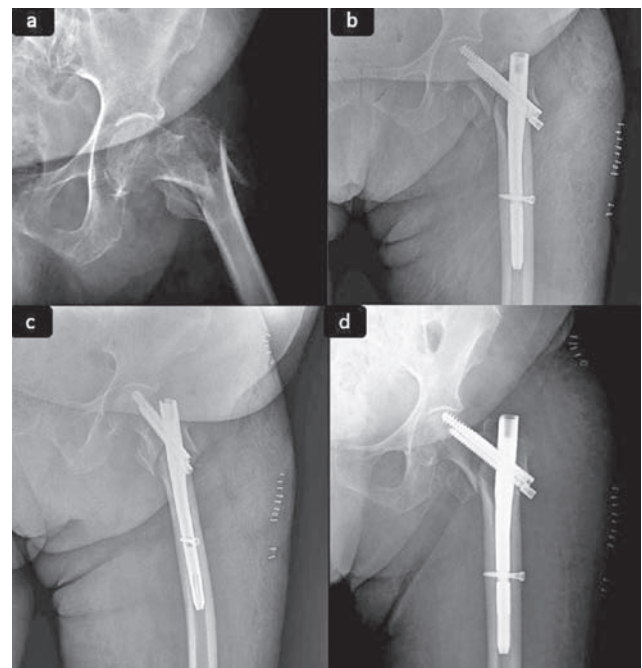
Varus Cut-off (a). Pre-operative X-rays (b and c). The fracture was fixed with negative medial cortical support, and the screws were placed high in the neck, both of which are risk factors for cut-out (b). AP view (c). Lateral view (d). Varus cut-off was seen at 2 weeks.
